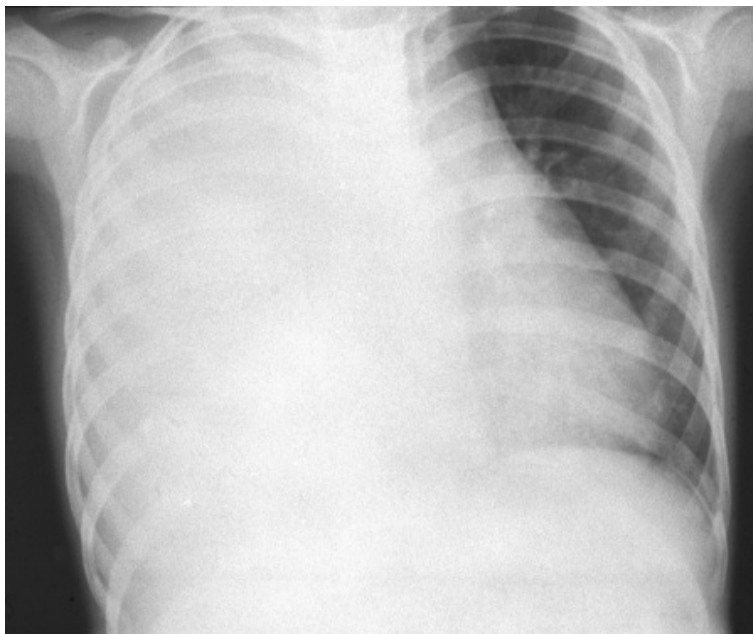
Chest x-ray of empyema
